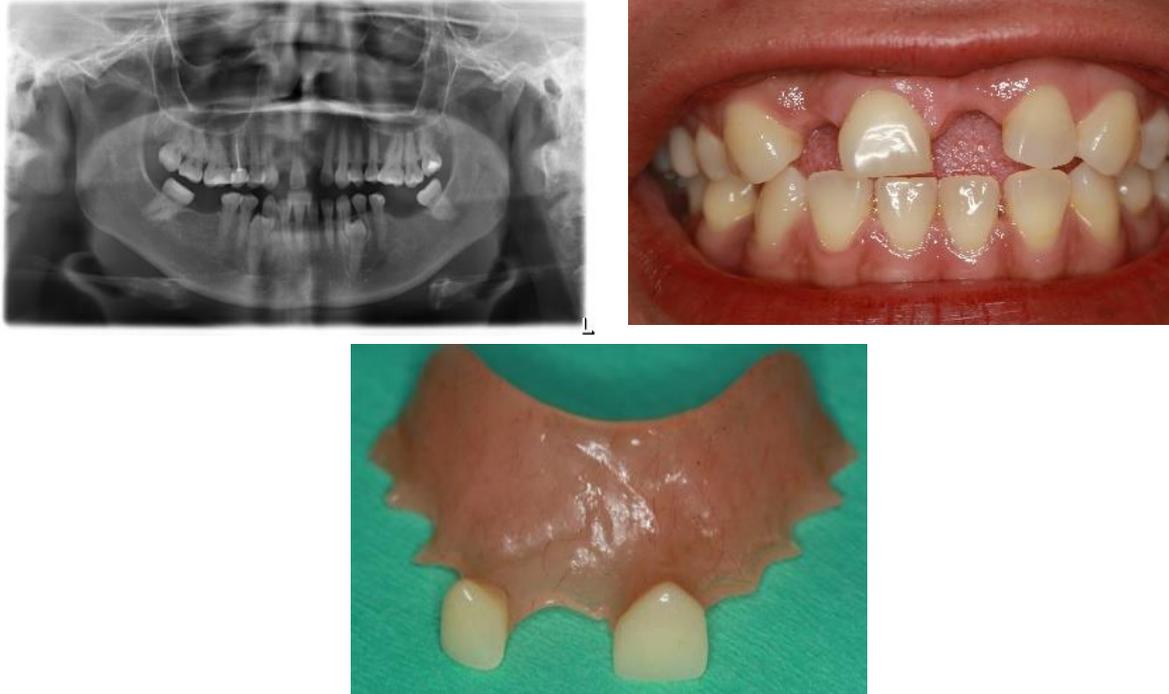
Panoramic radiograph and clinical photo of patient and partial prosthesis at presentation
